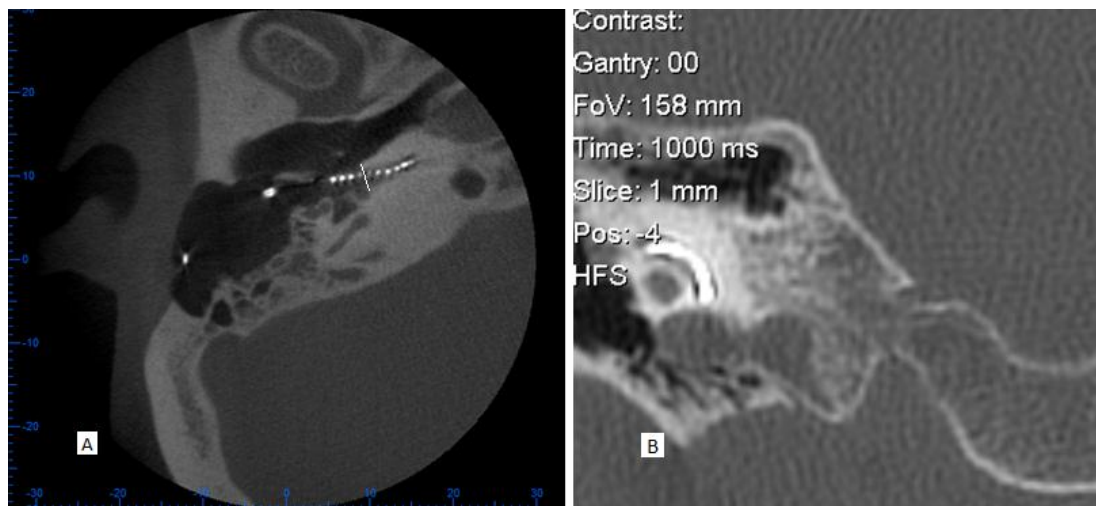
Examples of post CI CBCT and MSCT images. A) CBCT image of in an AB HiRes 90K implant electrode array which allowed the identification of individual electrode placement including the four extracochlear electrodes (as judged independently by both consultants and concurred later with the surgeon's report). B) MSCT image of a Nucleus® 22 electrode array intra-cochlear placement, individual electrode placement cannot be determined due to metallic artefacts.
